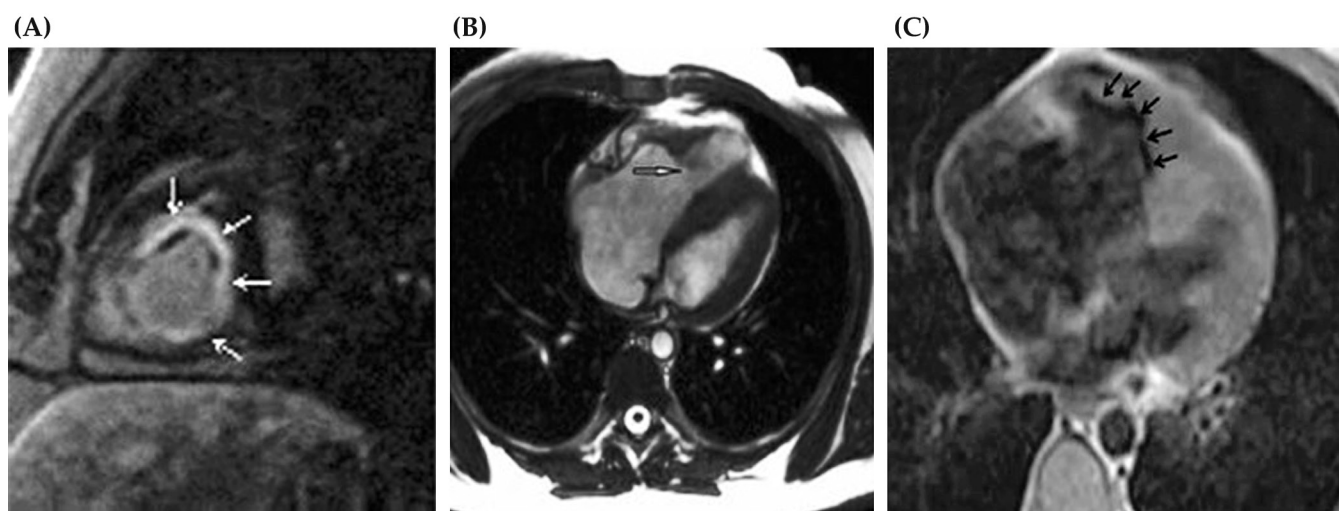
A case report of right ventricular endomyocardial fibrosis mimicking Ebstein anomaly in a 26-year-old Turkish male with Behçet disease [80]. (A) Turbo spin echo (TSE) T1 weighted axial magnetic resonance (MR) image showing low signal intensity (arrows) along the right ventricle endomyocardium indicating endomyocardial fibrosis. (B) Four-chamber cine MR denoting the downward displacement of the tricuspid leaflets (arrow), mimicking Ebstein anomaly. (C) Delayed-enhancement MR image of short axis showing subendocardial hyperenhancement of the right ventricle, suggestive of fibrosis. Adapted from Buturak et al. [80].
